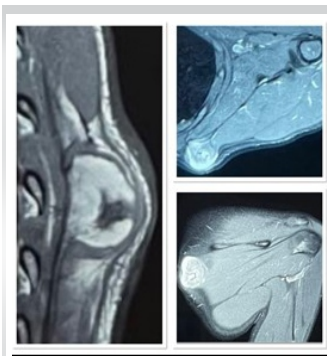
T2-weighted MRI images suggestive of hyper intense pedunculated osseous lesion arising from posteromedial aspect of the left scapula with no soft-tissue involvement.
